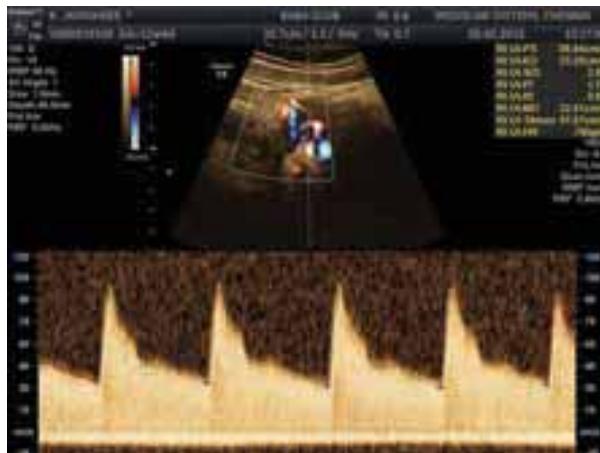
Uterine artery Doppler velocimetry. a. Normal pregnancy. Normal systolic and diastolic flow in uterine artery. b. Diastolic notching and high-resistance flow. The white arrows indicate diastolic notching. Pulsatility index is also high (2.45). (Photo courtesy: Mediscan Systems, Chennai.)
